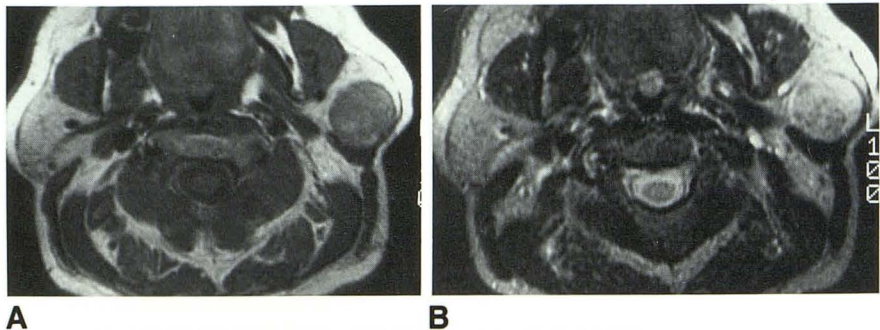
Pleomorphic adenoma with high conspicuity on both T1-weighted and T2-weighted images.
